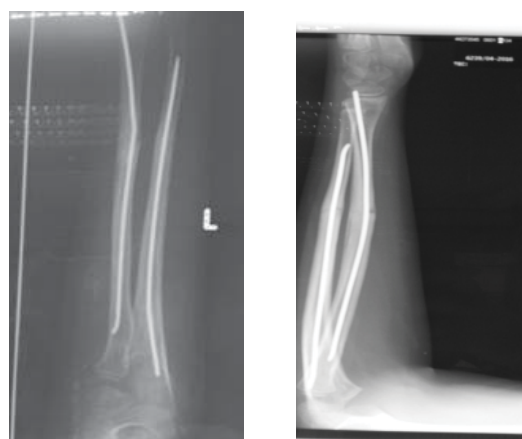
Post-operative x-rays radius/ulna at 12th week follow-up
